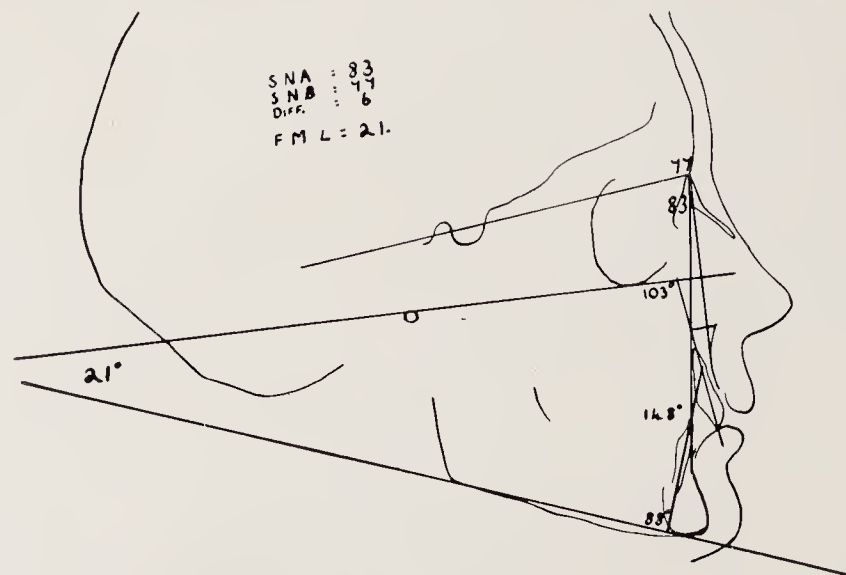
Tracing of cephalometric radiograph.
